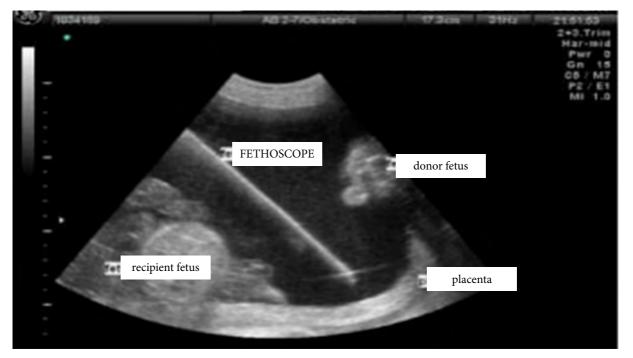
Ultrasonographic image of the fetoscope inside the uterine cavity. The fetoscope is facing the surface of the placenta and both fetuses can be seen in a cross-sectional view.
